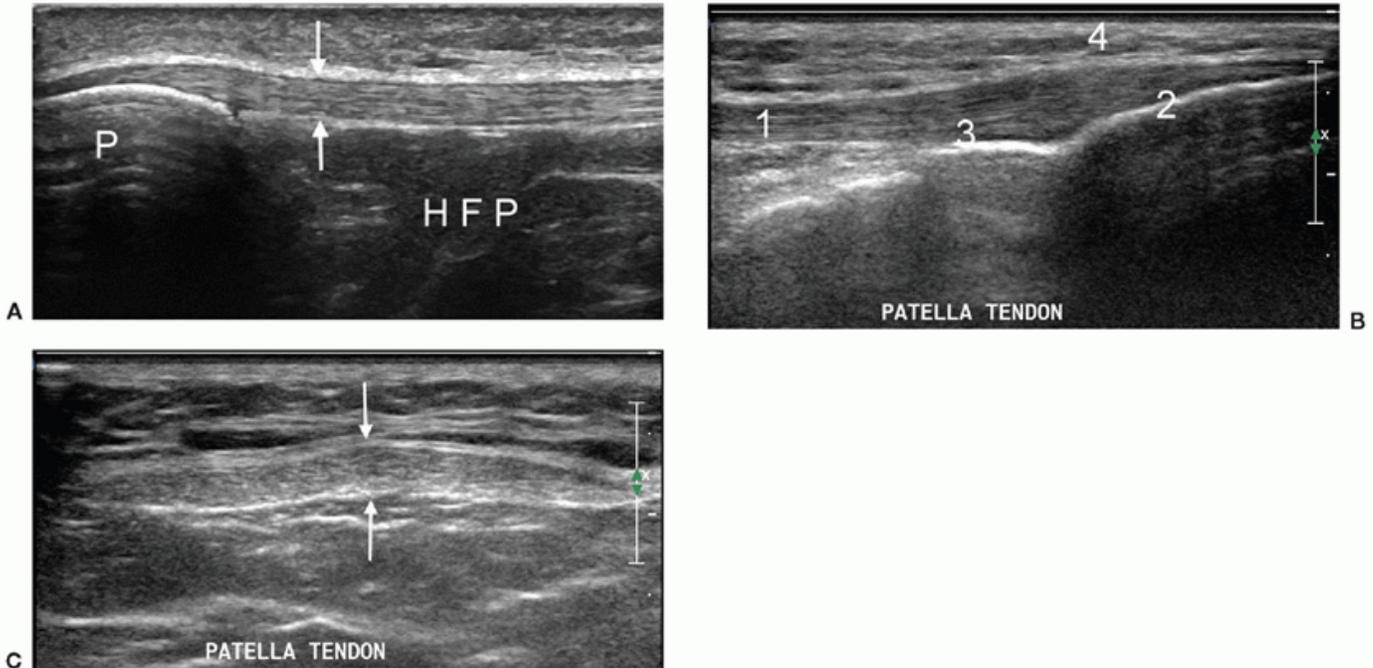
A: Normal longitudinal ultrasound image of the proximal patella tendon (arrows). P, patella; HFP, Hoffa fat pad. The tendon is well-defined and is uniform in caliber and texture. B: Normal longitudinal ultrasound image of the distal patella tendon (1). Tibial insertion of patella tendon (2). Deep infrapatellar bursa (3). Subcutaneous infrapatellar bursa (4). The tendon expands slightly as it runs to its insertion and often appears hypoechoic due to anisotropy. C: Transverse image demonstrating a normal patellar tendon (arrows). Note fine fascicle pattern.
